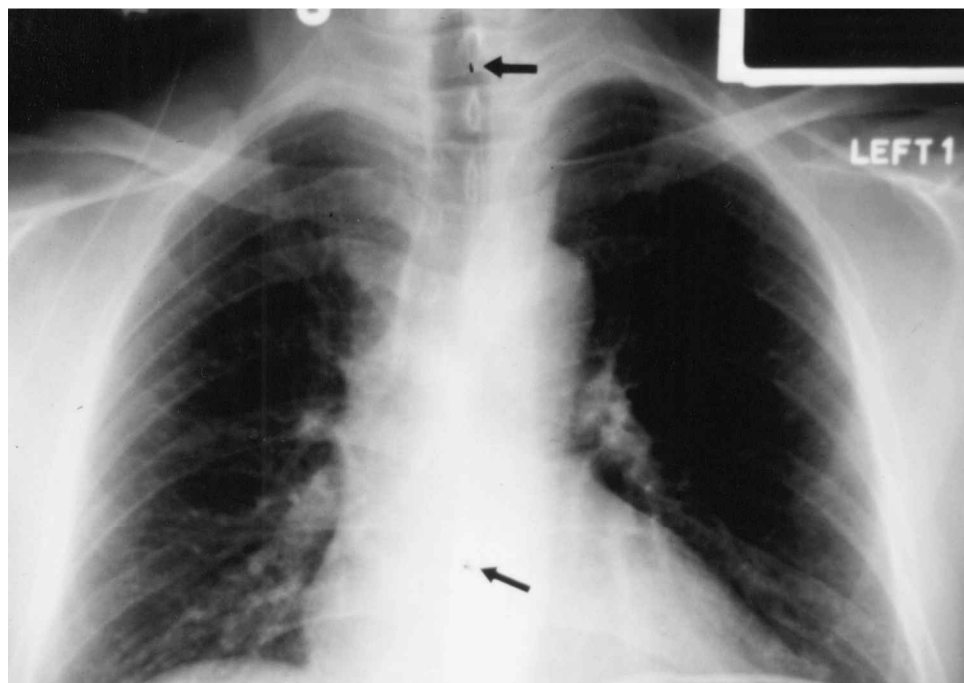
Ambulatory pH monitoring with dual pH sensors. Chest radiograph shows proper positions of two sensors.
